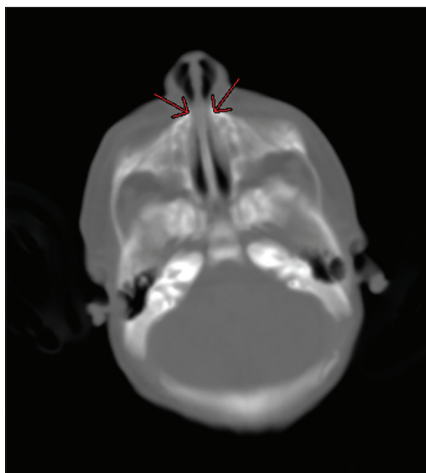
Axial computed tomography scan showing pyriform aperture stenosis
